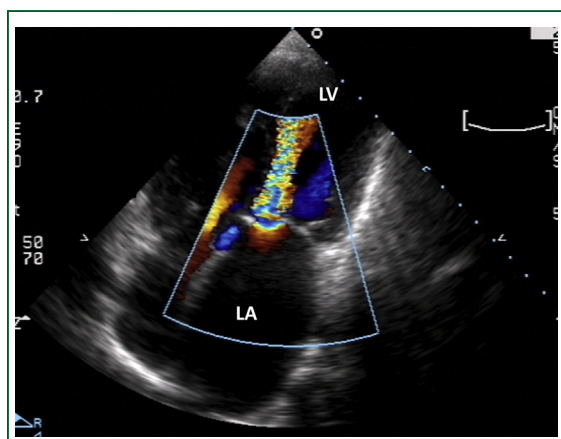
Color Doppler across mitral valve in a patient with mitral stenosis. Abbreviations as in Figure 1.
